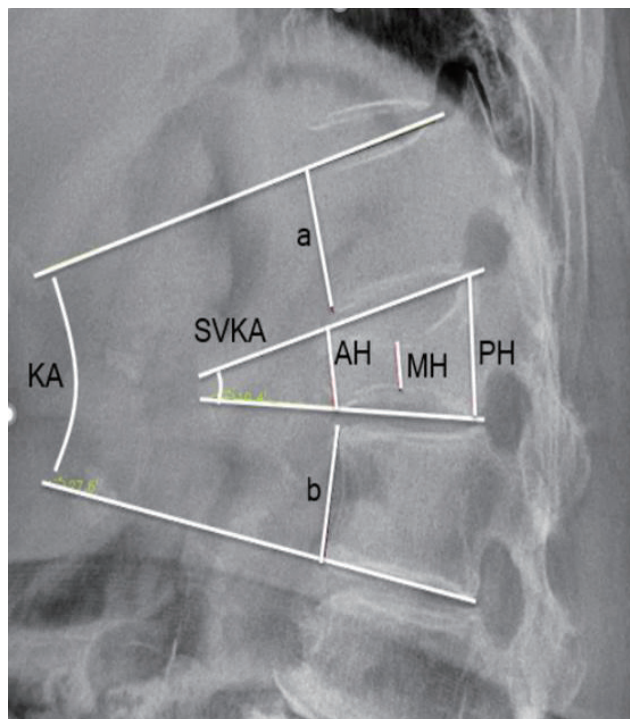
Measurement of radiological parameters on sagittal plain X-ray. Kyphotic angle (KA) is the angle between the upper endplate of the vertebra above the fractured vertebra and the lower endplate of the vertebra under the fractured vertebra. Segmental vertebral kyphotic angle (SVKA) is the angle between the upper and lower endplate of fractured vertebra, compression ratio (CR) is the percentage of anterior vertebral body compression with respect to the average height of anterior vertebra bodies just above and below to the fractured vertebra ($1 - [2AH / a + b] \times 100\%$). Vertebral body height was measured at the anterior (AH), middle (MH), posterior (PH) borders.
